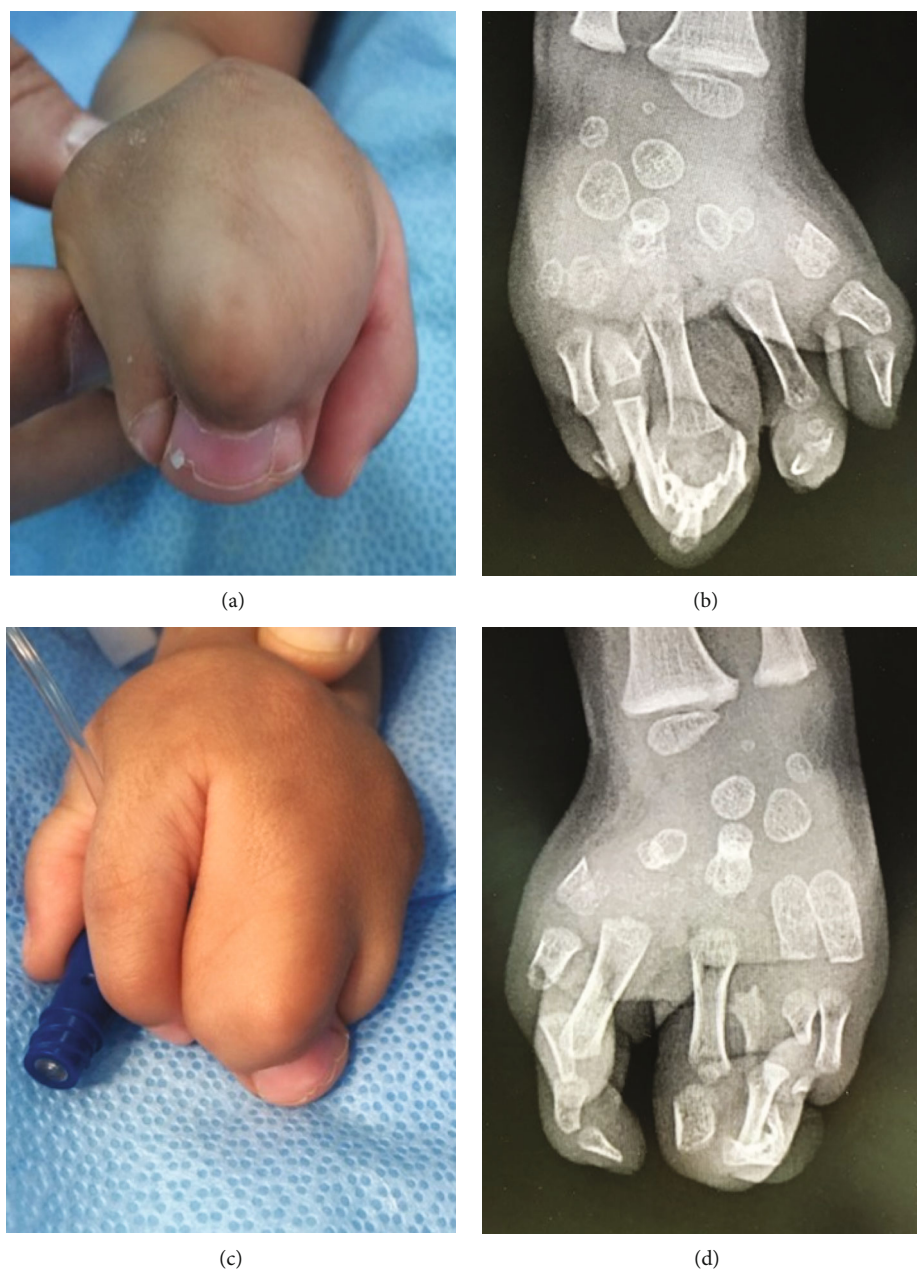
The hands of the homozygous child: (a) clinical appearance of the right hand showing syndactyly of all fingers and “cupping” of the hand; (b) X-ray of the right hand (after surgical separation of the index finger). Note that the metacarpals have attained the shape of carpal bones; (c) clinical appearance of the left hand showing syndactyly of the middle, ring, and little fingers; (d) X-ray of the left hand also showing a metacarpal-to-carpal transformation.
